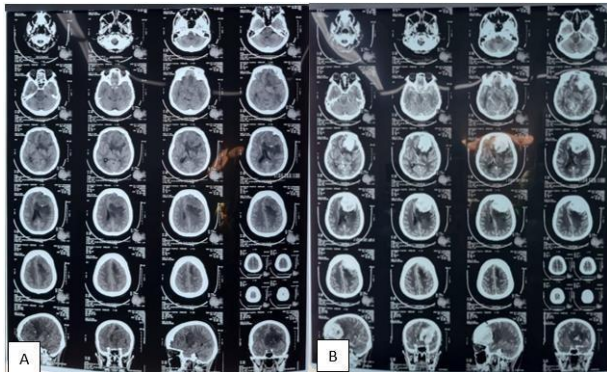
A. Non Contrast CT Scan, B. Contrast CT Scan
